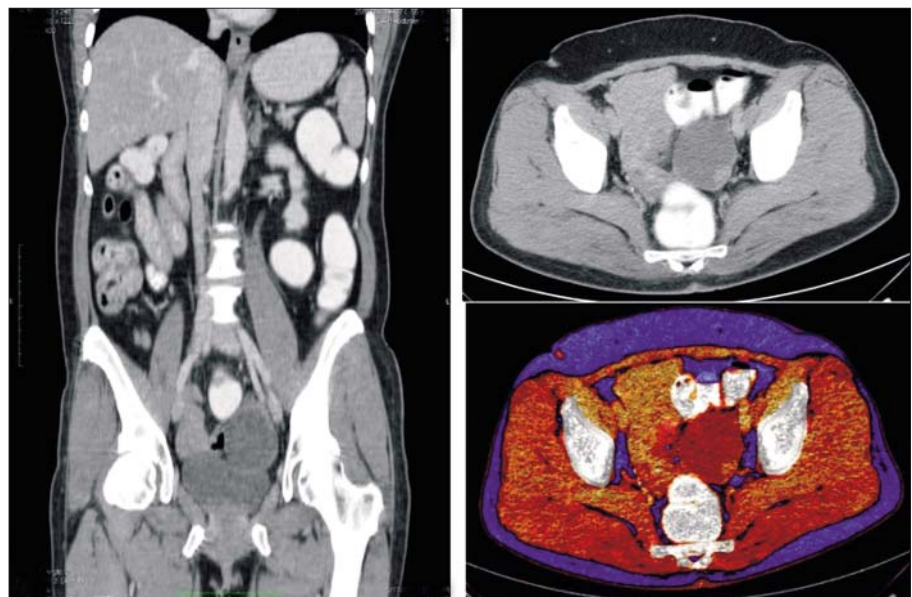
CT findings - for topography of the left ovary a 63/57/71 mm well-defined cystic mass, with a non-uniform wall thickness in contact with the superior ovarian vessels, lower is adjacent to the vagina, anterolaterally right on a small area of sigmoid or ileal loops and on the left side widely adjacent to the parietal pelvic peritoneum
